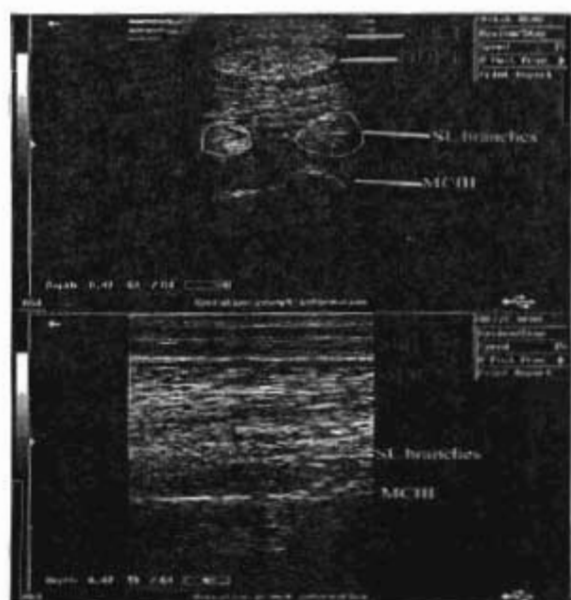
Transverse (A) and longitudinal (B) sonogram of the normal flexor tendons in the distal metacarpal/metatarsal region showing the normal echogenicity and fiber alignment of the SDFT, DDFT, ICL and SL branches.
